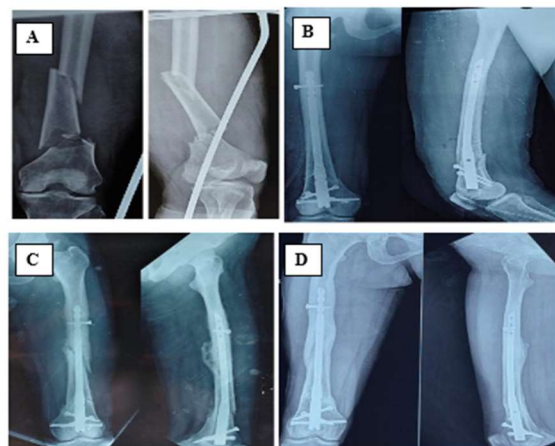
(A) PRE-OPERATIVE XRAY, (B) POST OP XRAY, (C) POST OP XRAY AT 3 MONTHS, (D) POST OP XRAY AT 6 MONTHS
